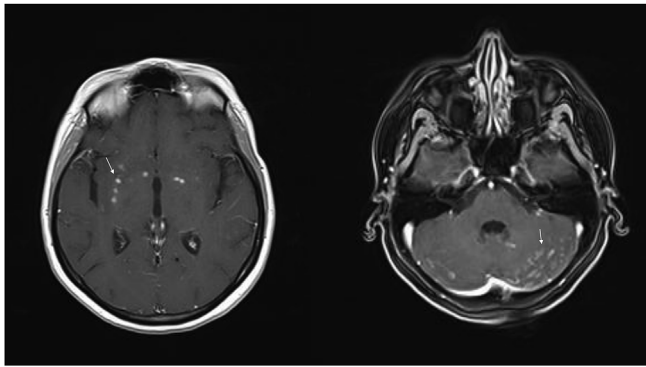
Magnetic resonance imaging: Multiple cryptococcoma lesions in the cerebellar hemispheres, the internal capsule and the left hypothalamic nucleus (arrows). After the administration of paramagnetic drug, meningeal enhancement was detected.
